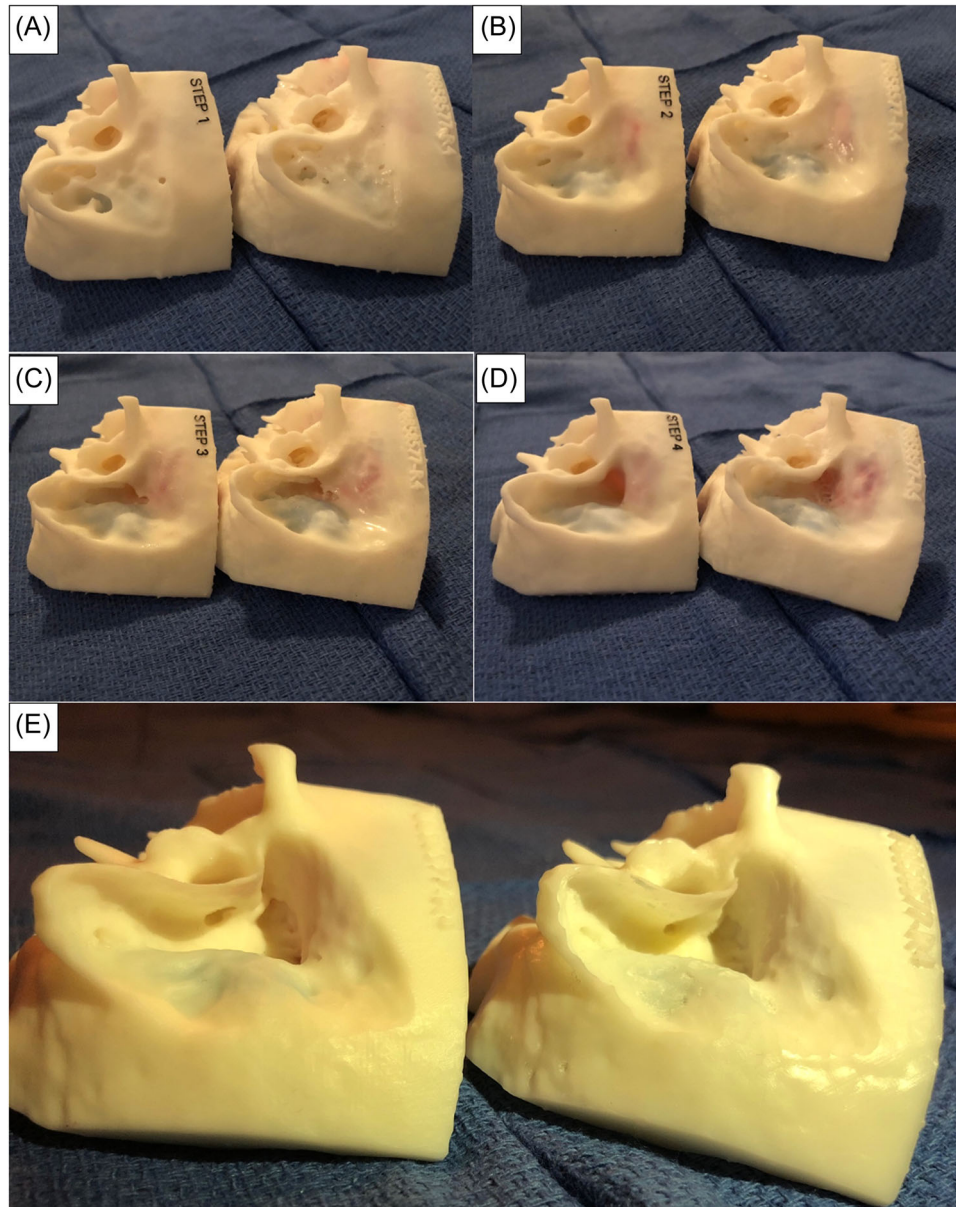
Drilled models alongside the 3D-printed copies. The drilled original models are on the right side while the copies made from CT scans of the originals are to the left. (A) Step 1: Removal of cortex and cavity saucerization. (B) Step 2: Identification of the sigmoid sinus and middle fossa dura plate. (C) Step 3: Entering the antrum. (D) Step 4: Completing the basic mastoidectomy. (E) Step 5: Drilling the facial recess. 3D, 3-dimensional; CT, computed tomography.
